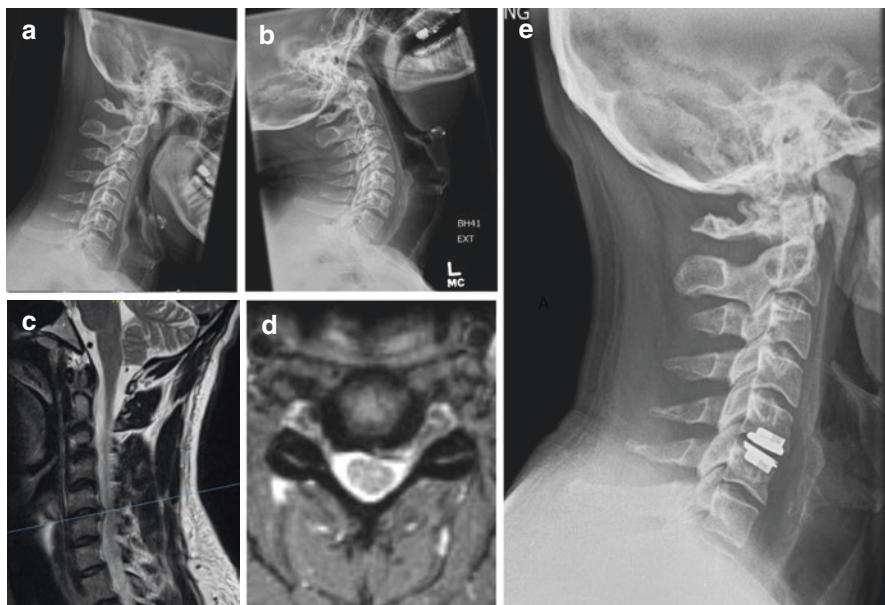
This is a case presentation of a 21-year-old elite baseball player who presented to our clinic with 8 weeks of left C6 radiculopathy. He had no weakness on examination. He was unable to participate in his off-season workout despite extensive conservative treatment. Panels (a, b) show lateral flexion/extension radiographs demonstrating full range of motion with minimal spondylosis. Panels (c, d) show a T2-weighted cervical MRI demonstrating a soft paracentral disc herniation on the left at C5-6. After extensive discussion with the patient, he elected to move forward with a CDA for surgical treatment. Panel (e) shows the post-op radiograph at 6 weeks demonstrating the C5-6 CDA. The patient was released to return to play at 3 months when the patient had full range of motion, no pain, and no persistent neurologic symptoms
